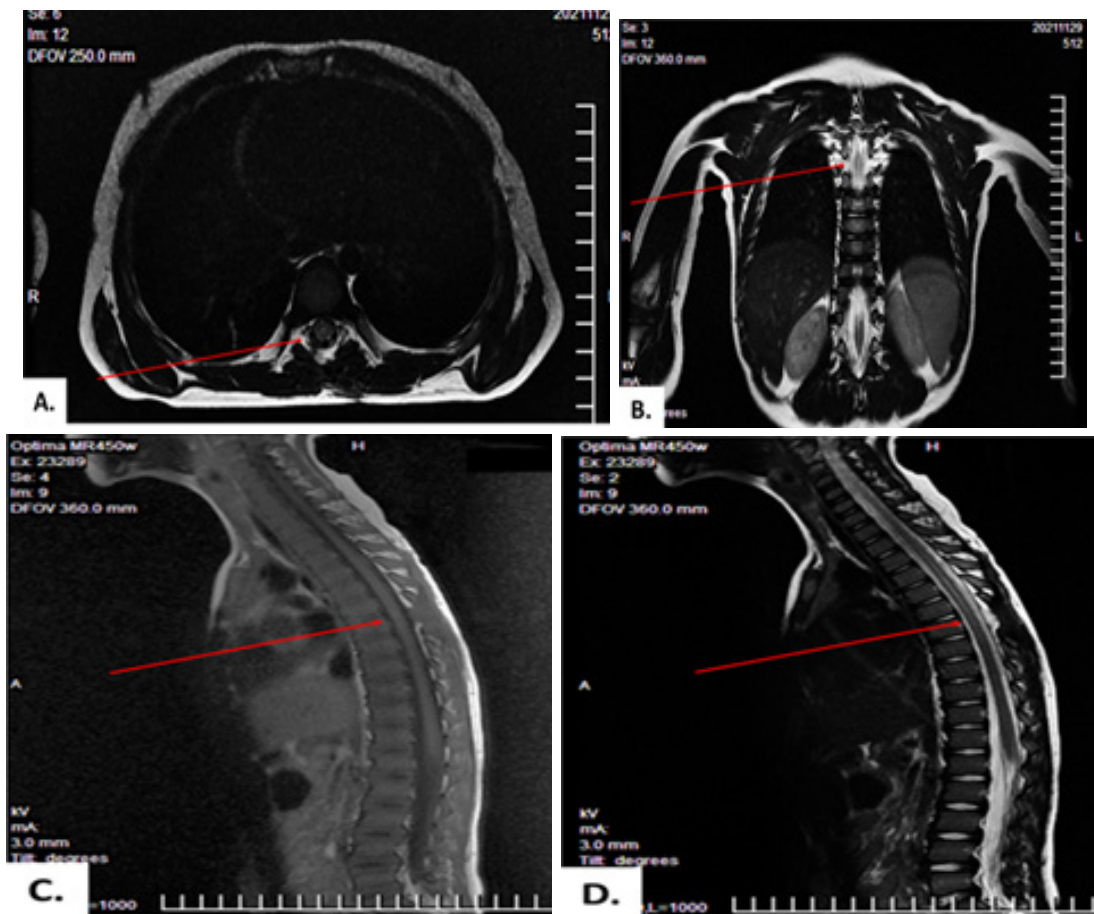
MRI gram after surgery. MRI signs of SPE after removal of an extradural extramedullary mass at the level of the bodies of Th6-Th8 vertebrae (the spinal cyst is not detected, there are no signs of recurrence). MRI scans: T1 axial (A), T1 coronal (B), T1 sagittal (C) and T2 sagittal (D).
